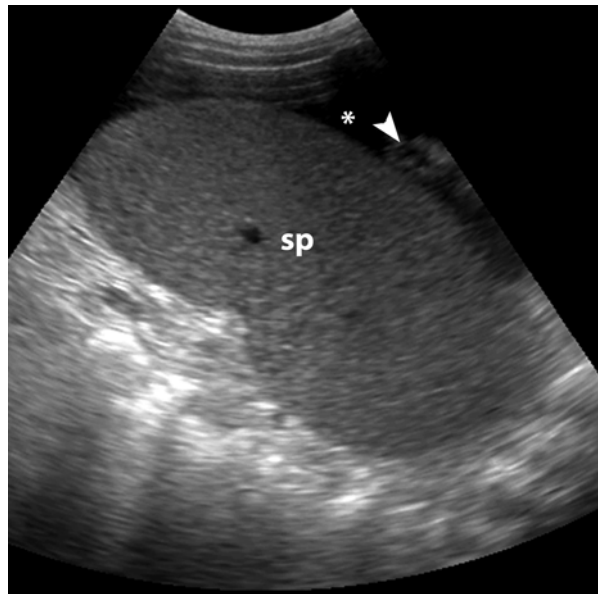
Free fluid and hemoperitoneum on Focused Assessment by Sonography for Trauma (FAST) examination. Ultrasound image of the left upper quadrant demonstrates fluid (asterisk) and a small amount of hematoma (arrowhead) adjacent to the spleen (sp) due to a small splenic laceration
